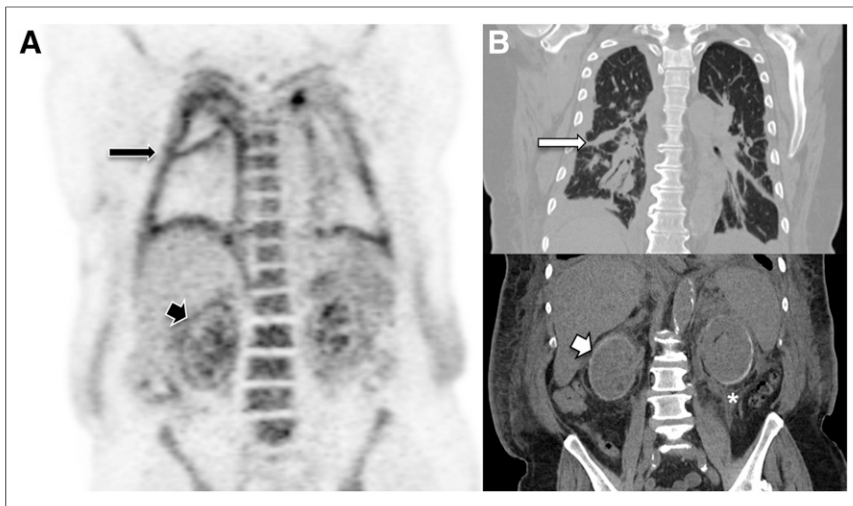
71-y-old man with shortness of breath. (A) Coronal PET demonstrates increased pleural (long black arrow) and renal (short black arrow) ^{18}F -FDG activity. (B) Corresponding coronal CT depicts pleural thickening (long white arrow), bilateral perinephric fat stranding (hairy kidney) (*), and renal cortical calcification (goose egg kidney) (short white arrow).
